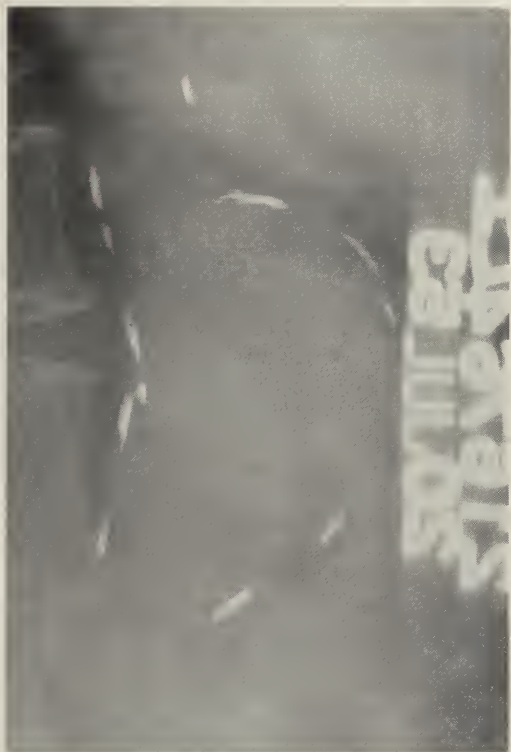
Lateral roentgenogram of abdomen. A rim of calcification about the aneurysm which lies immediately anterior to the bodies of the lumbar vertebrae is shown.
